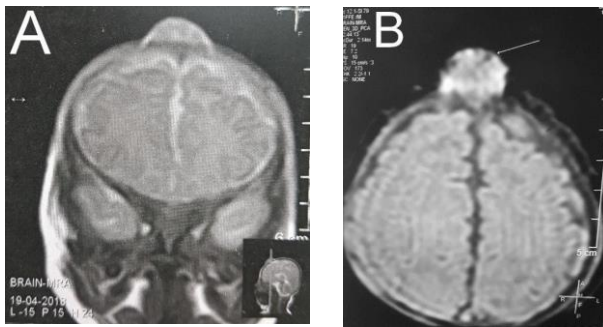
MRI T2 coronal (A), and axial T1 of two different cases showing midline SP related to SSS.
